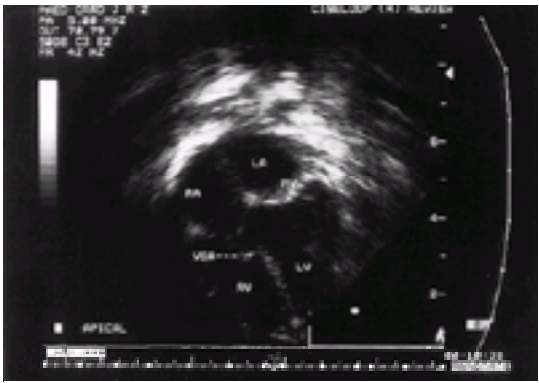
Apical four chamber ultrasound scan showing perimembranous ventricular septal defect with tricuspid valve tissue partly occluding it by forming a so-called aneurysm. LA, left atrium; RA, right atrium; LV, left ventricle; RV, right ventricle; VSA, ventricular septal aneurysm.
